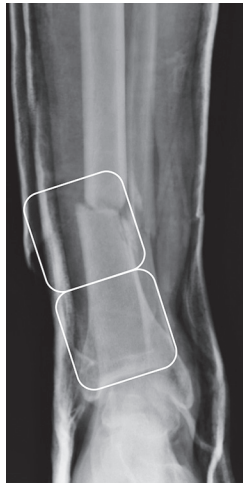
An AP radiograph taken at the time of injury demonstrating a distal tibia fracture within 2 Müller squares
